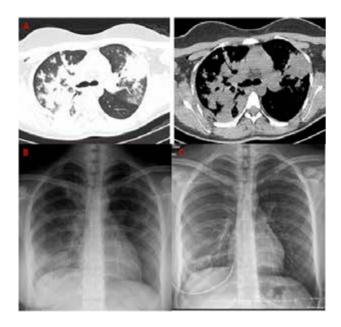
A. Postoperative 4th day thorax CT. B. Discharge chest X-ray. C. Chest X-ray 1 month after discharge
